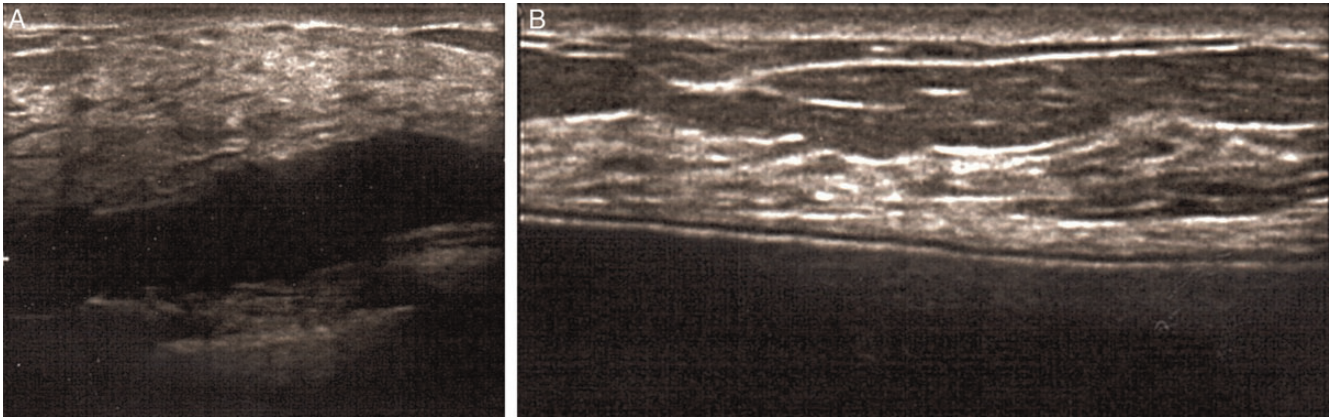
(A) Preoperative and (B) 6-month postoperative breast ultrasounds of this 35-year-old woman who underwent removal of Macrolane-containing cysts and breast augmentation. Note removal of cysts containing Macrolane in the postoperative sonogram.
